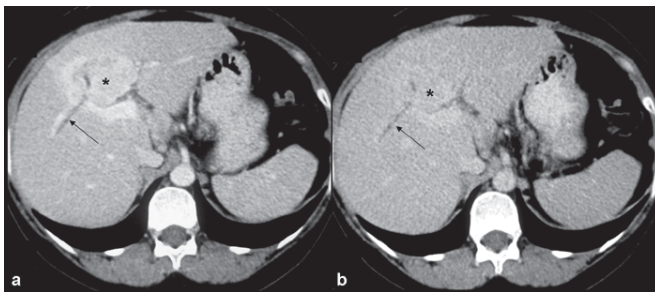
Axial contrast-enhanced CT shows a mass anterior to the portal vein (asterisks) that shows enhancement in the venous (a) as well as delayed (b) phases. Associated biliary ductal dilatation (arrows) suggests the possibility of an intrahepatic cholangiocarcinoma.
